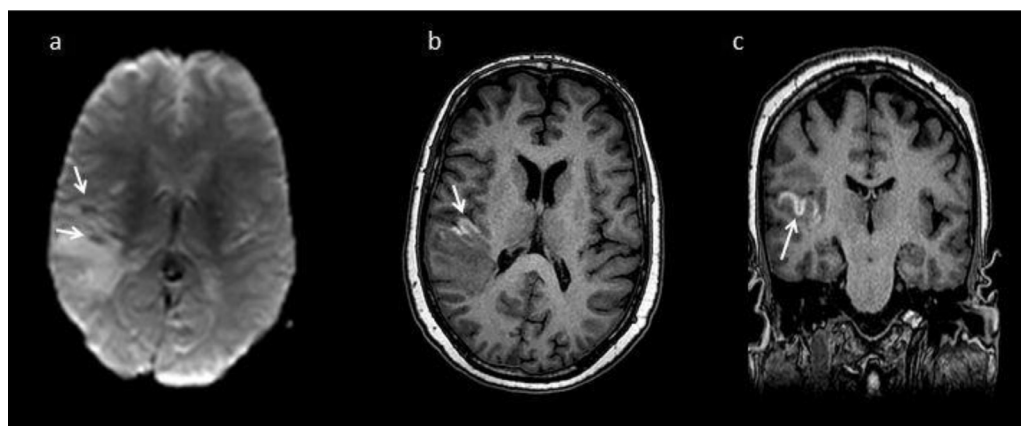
The signal changes in GRE T2* and T1-weighted image. (a) GRE T2*-weighed image, (b) axial GRE T1-weighted image, (c) coronal GRE T1-weighted image. The white arrows show small intraparenchymal hemorrhages.
